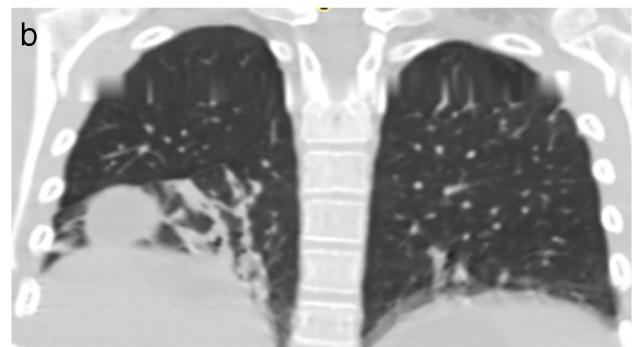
Disseminated hydatid disease in a 12-year-old girl. a Sagittal and (b) coronal contrast-enhanced CT reformatted images show trans-diaphragmatic migration (*white arrow*)
